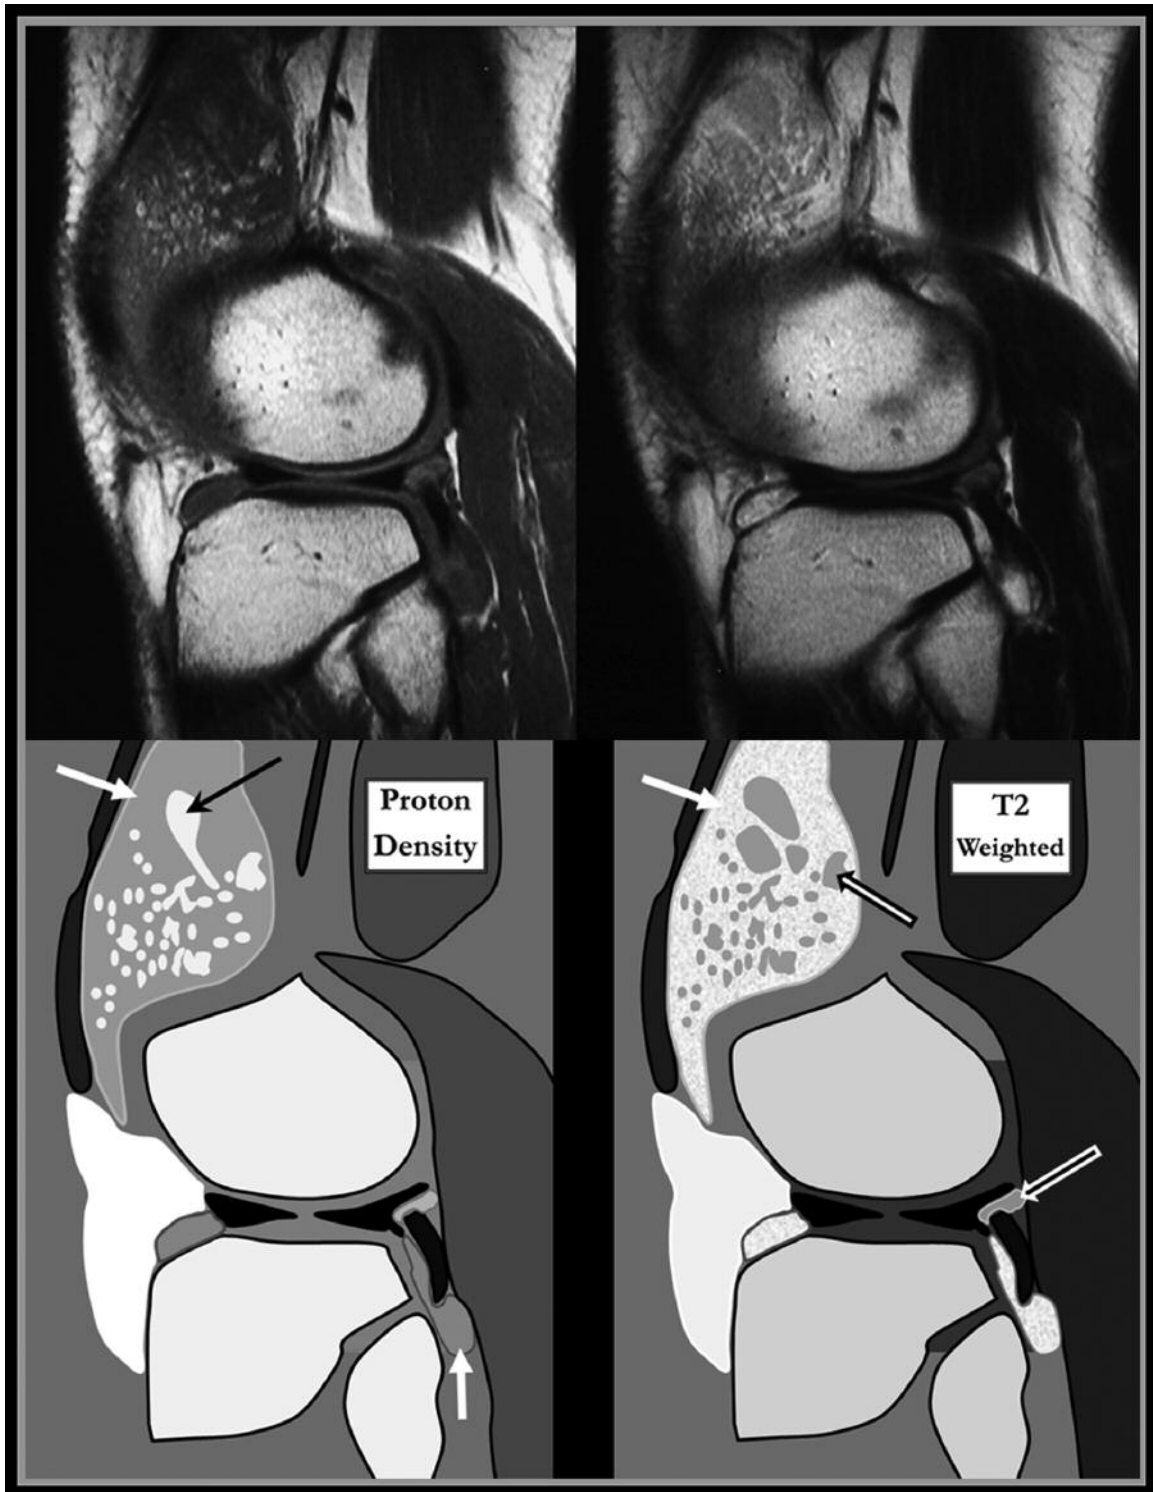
On magnetic resonance imaging, synovial fluid in the knee joint appears grey in signal intensity on proton density images (PD; left panels) and bright on T2 weighted images (T2w; right; white arrows at suprapatellar bursa and popliteus tendon sheath). Synovial thickening is usually isointense to joint fluid on PD, but is grey on T2w images and stands out from the synovial fluid on this sequence (black-white arrows on T2w at suprapatellar bursa and popliteus tendon sheath). In our case, multiple small foci of bright signal intensity are seen in the synovial space on the PD image. This is typical of fat signal arising from the synovium in lipoma arborescens (black arrow).
